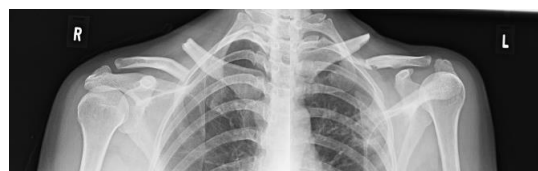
Patient preoperative xray
